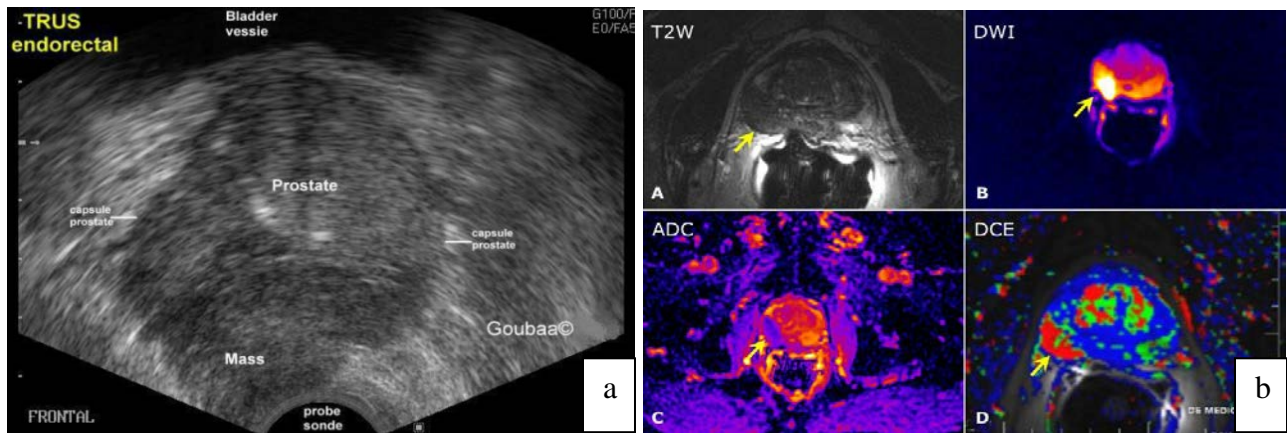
Prostate Cancer Detecting Images (a) typical TRUS, and (b) various multi parametric MRI for lesion identification.[1, 2]
